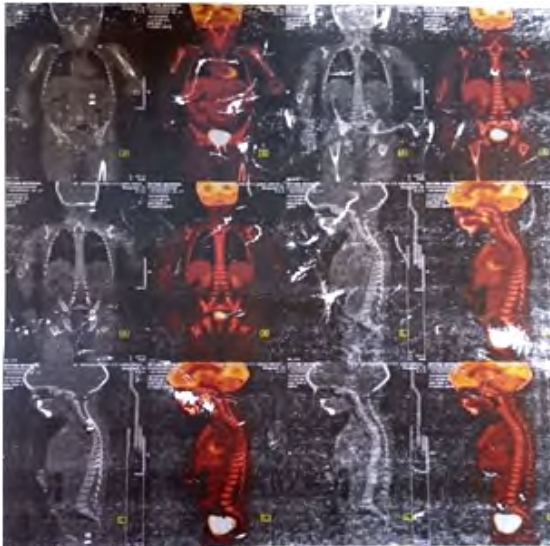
PET CT Scan showing Isolated Mandibular Involvement
